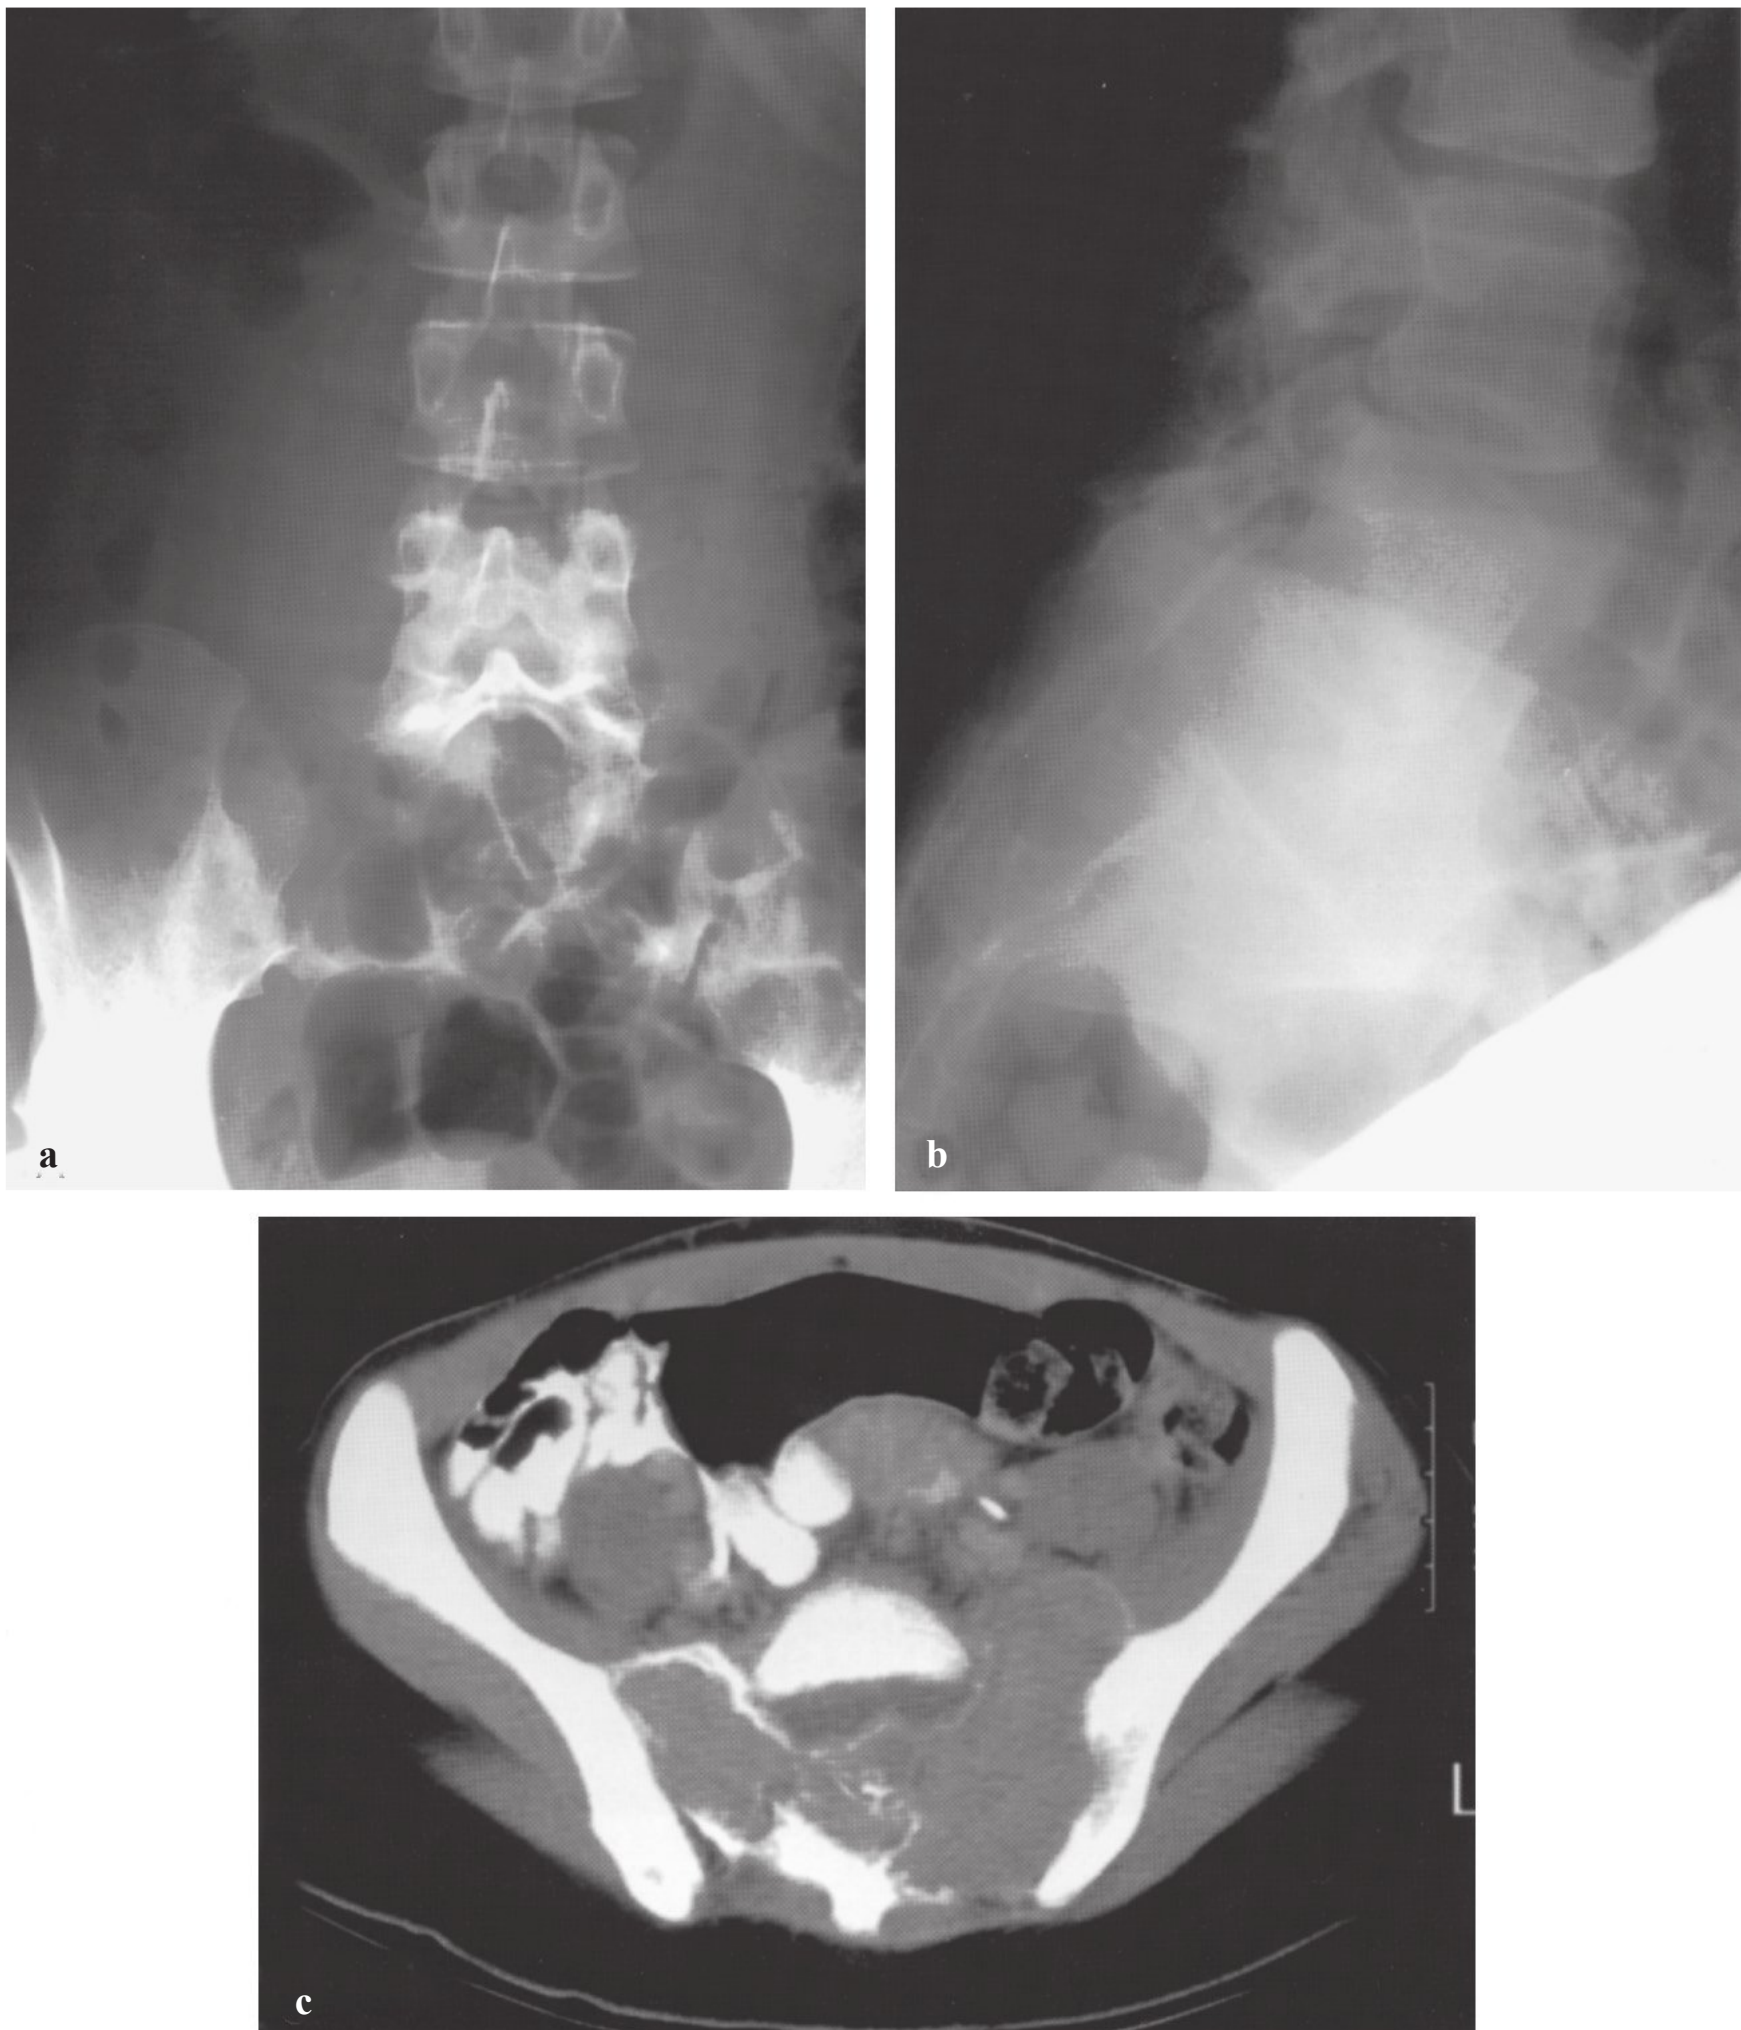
Images of a 17-year-old girl with giant cell tumor involving the sacrum. (a) Anteroposterior view of the spine and pelvis showing a destructive lesion involving the sacrum and left sacroiliac joint. (b) Lateral radiograph showing a destructive lesion at S1–S2. Note that the sacrum is not well demarcated. (c) Computed tomographic scan showing the extent of the tumor with involvement of the left sacroiliac joint.
